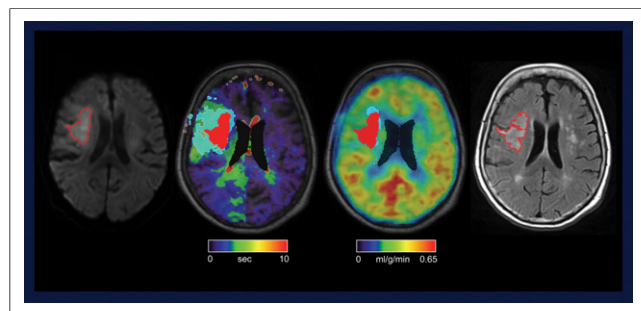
Simultaneous ^{15}O -H $_2$ O PET/MR in acute stroke. Left to right: infarction core (DWI MR); MR penumbra (MR contrast media dynamics); PET penumbra (CBF as determined by H $_2$ O kinetic modelling), and outcome (FLAIR MR) on d 6.
